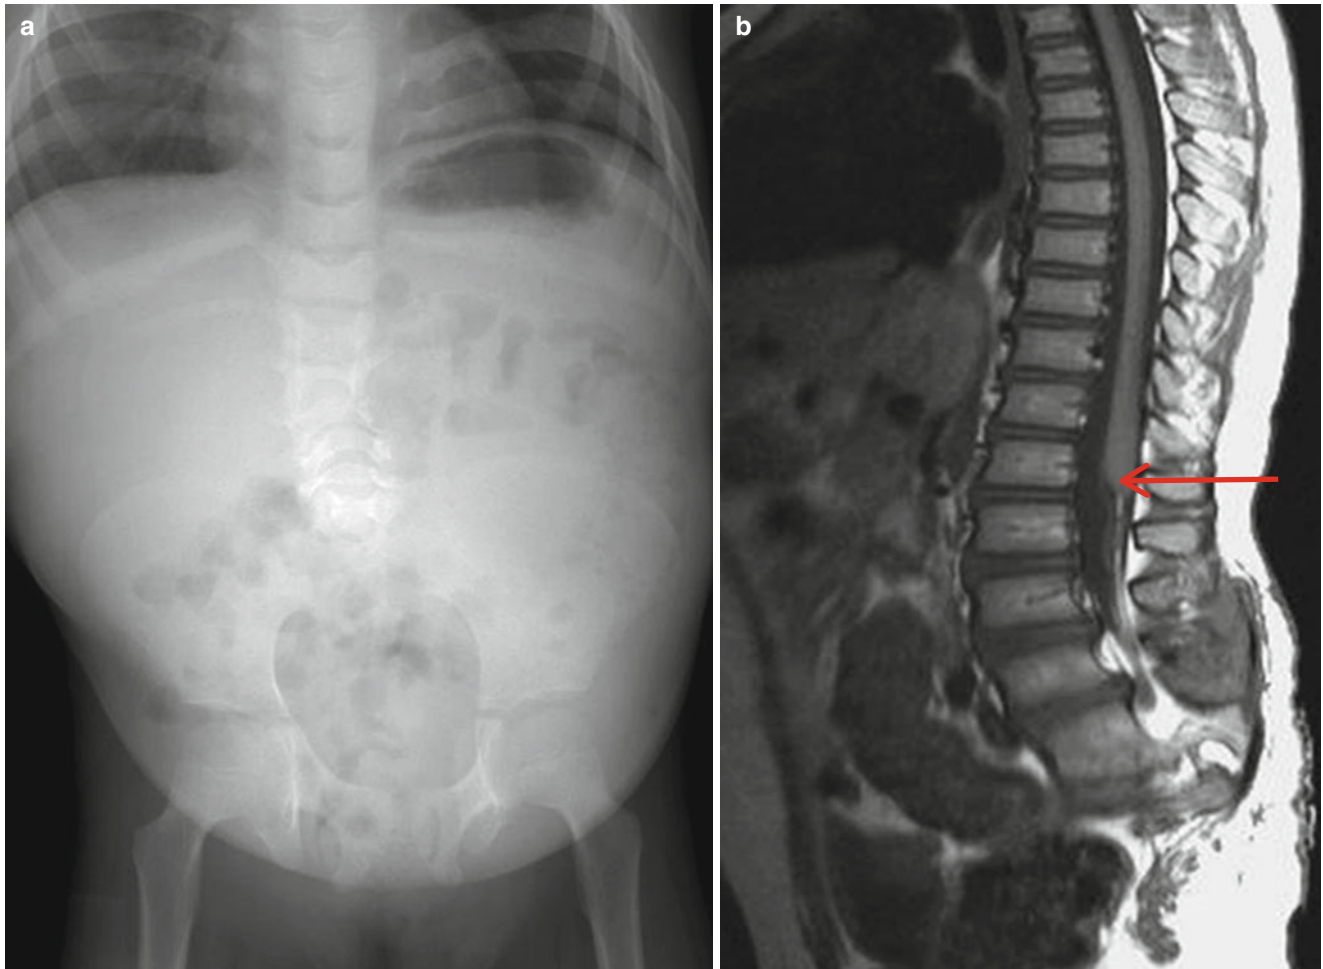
Caudal regression syndrome. (a) Plain radiography shows close opposition of the ilium due to sacral agenesis. (b) Mid-sagittal image shows slanting (*arrow*) of the conus posteroinferiorly instead of normal cone shape and fatty filum. Sacrum and posterior neural arch of the distal lumbar spines are not formed
